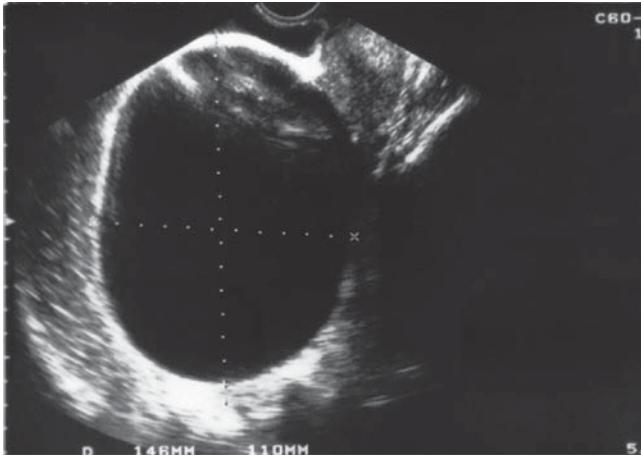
Ultrasonographic scan of a large solitary luteinized follicular cyst of pregnancy and puerperium
